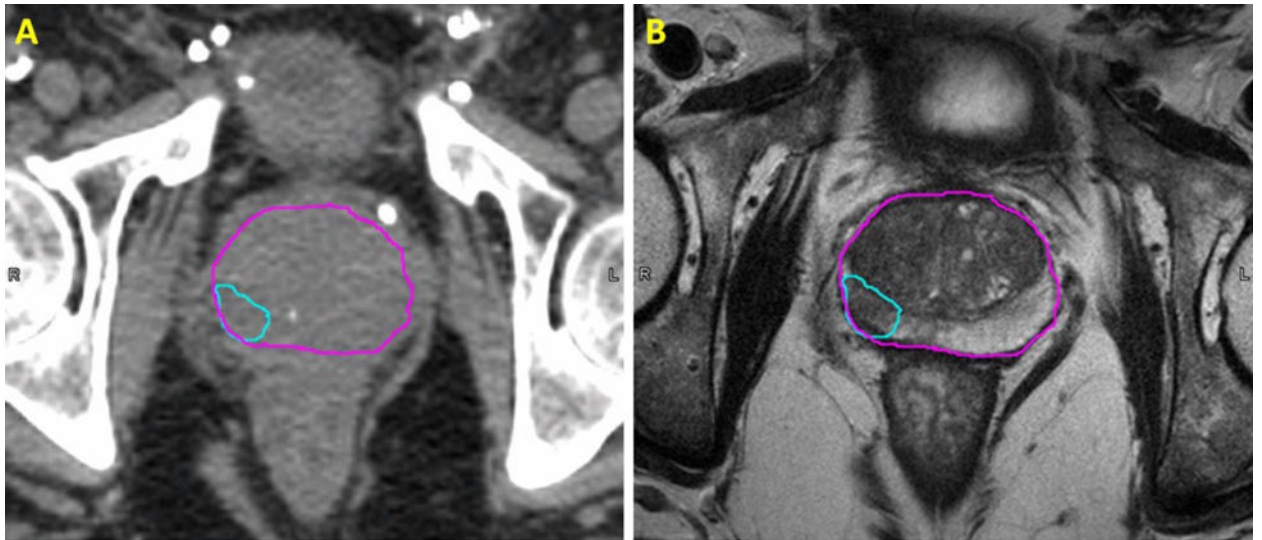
Comparison of the transverse view of CT (left) and T2-weighted (right) images of a patient with prostate cancer; The volumes are as follows: prostate (magenta) and dominant intraprostatic lesion (cyan).
